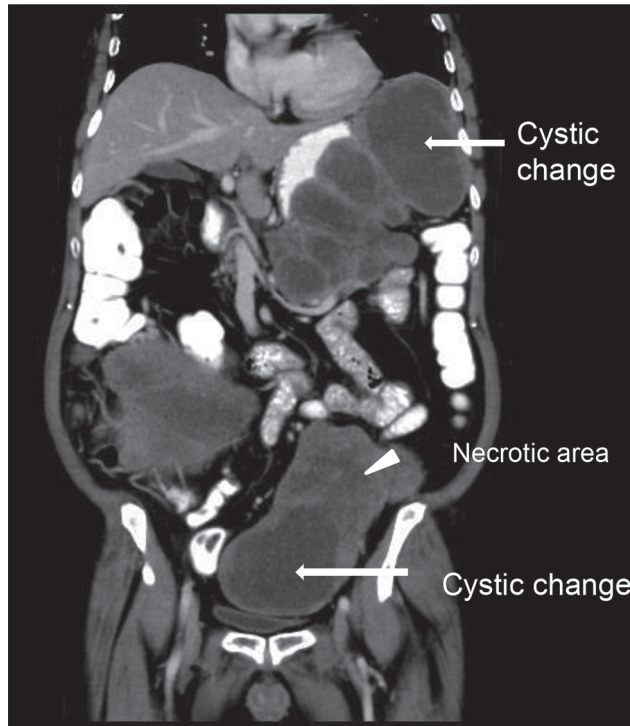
Coronal contrast-enhanced CT image showing large exophytic gastric gastrointestinal stromal tumor (GIST) with predominant cystic change and multiple peritoneal deposits. Pelvic metastatic deposit shows necrotic area as well as cystic change. High risk. Mitotic index (MI): $> 5/50$ HPF. Size 19.1 cm (white arrows point to cystic change and white arrowhead points to necrotic area).
